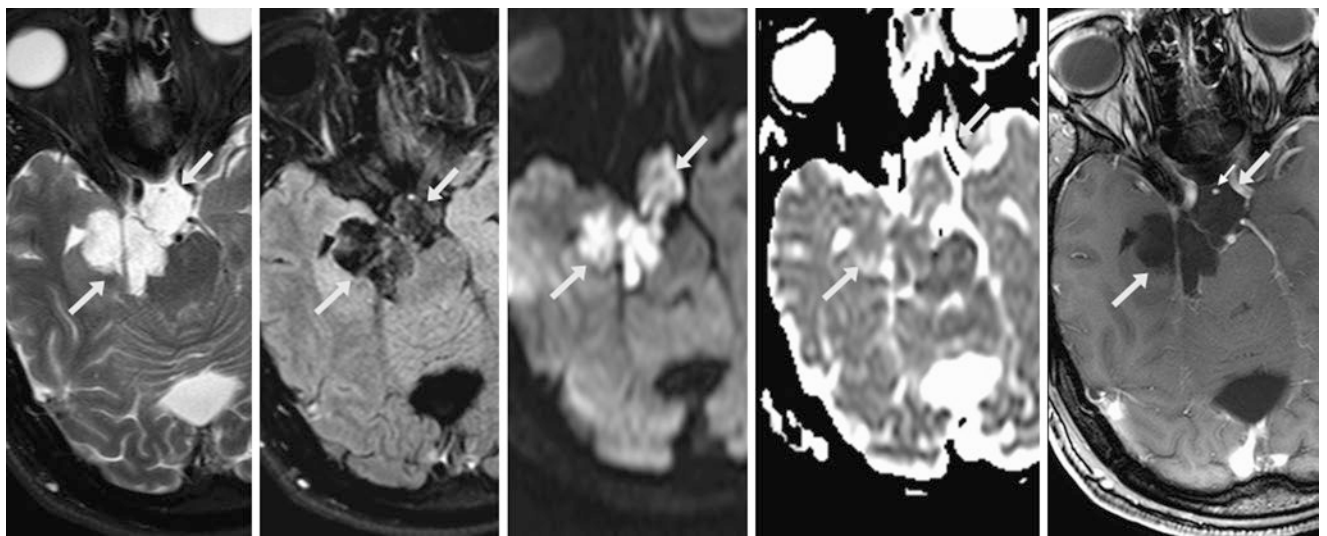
Comparison case of epidermoid cyst. A 27 year old underwent a 1.5 T MRI, including axial T2WI (*left*), postcontrast FLAIR (*left middle*), DWI (*middle*), ADC map (*right middle*), and postcontrast T1WI (*right*), which showed a T2-bright cystic mass (*arrows*) within the right perimesencephalic cistern and the suprasellar cistern that
